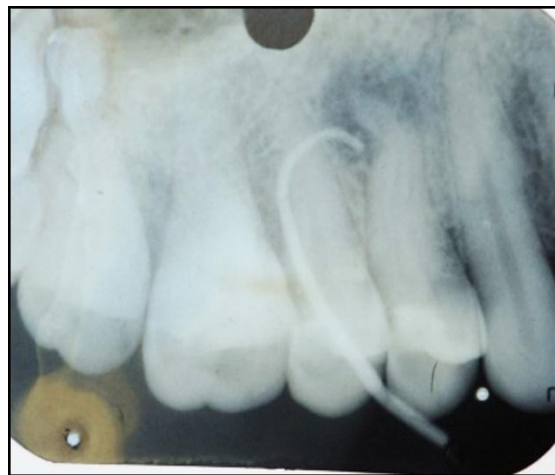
Radiograph showing sinus tract tracing using GP
